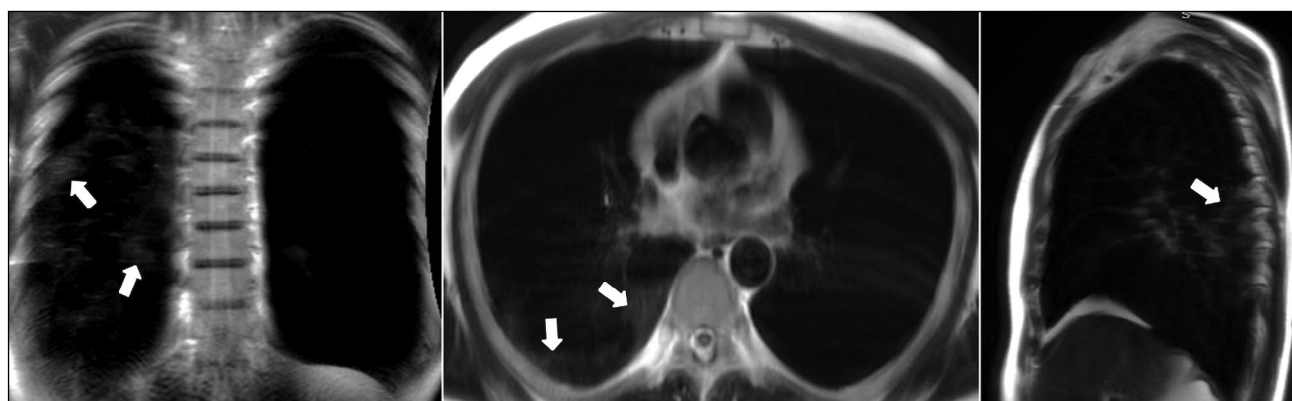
Dynamic magnetic resonance imaging of the lungs during inhalation in the coronal, axial, and sagittal planes. Arrows point to areas of low-intensity signal with the “cloudy sky” pattern (S6, S9, and S10).
